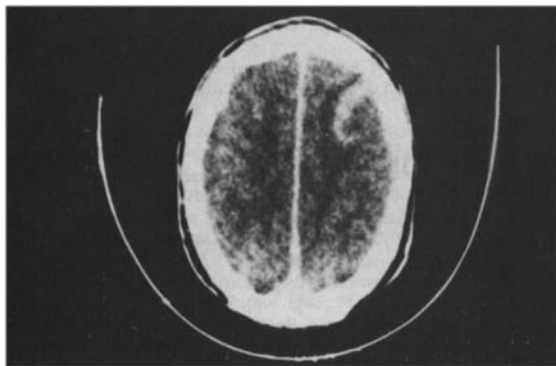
Post-contrast CT Scan of Patient 1 showing a crescentic area of uptake in the left fronto-parietal region.
